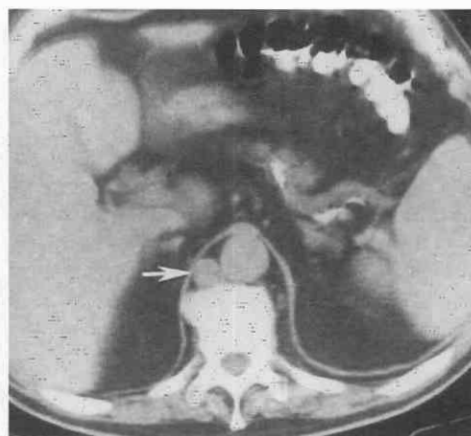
Azygous continuation of the inferior vena cava. Nondynamically enhanced CT scan demonstrates marked enlargement of the azygos vein (arrow). The subhepatic, suprarenal portion of the inferior vena cava is absent.
